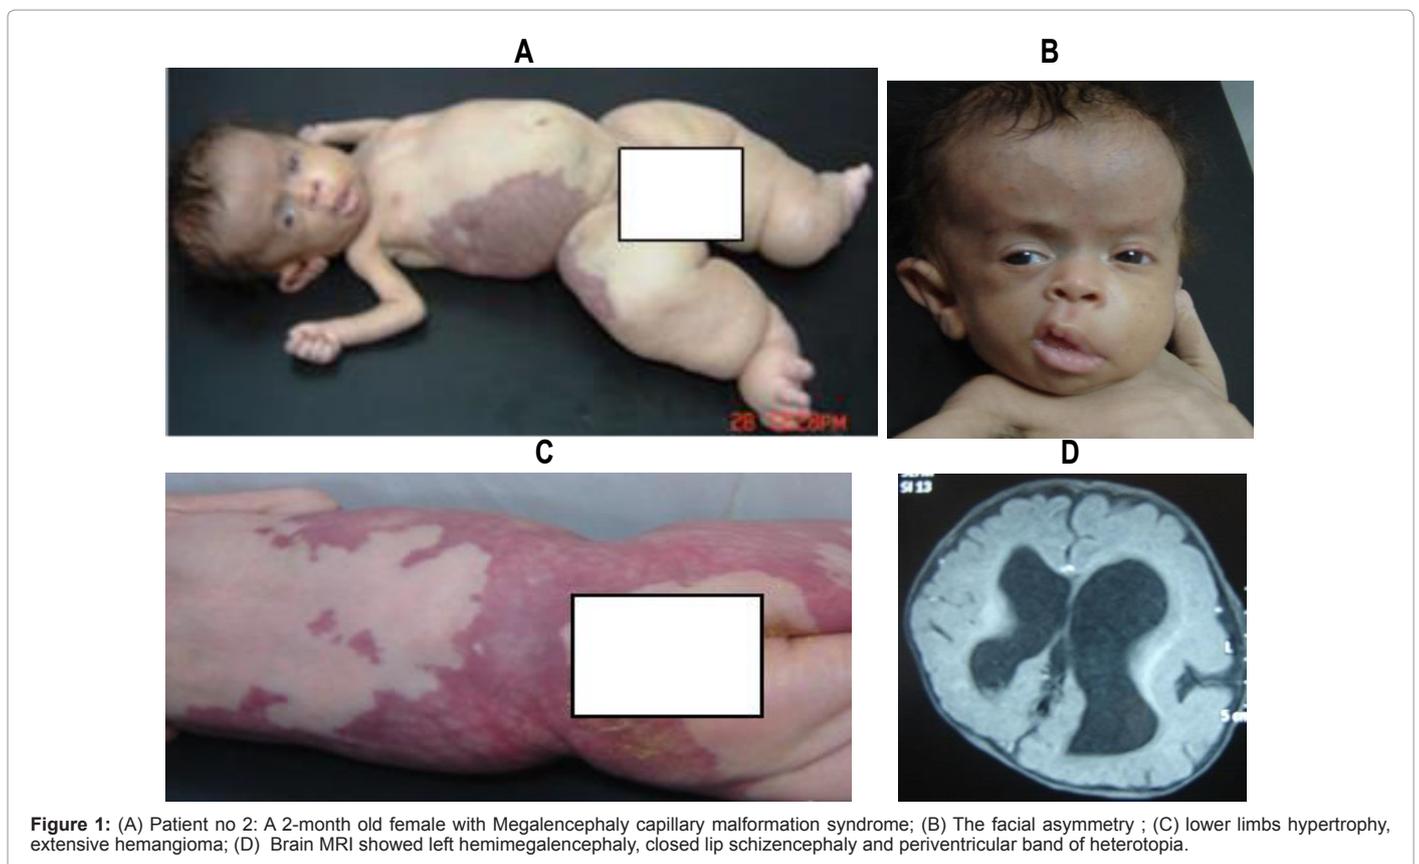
(A) Patient no 2: A 2-month old female with Megalencephaly capillary malformation syndrome; (B) The facial asymmetry ; (C) lower limbs hypertrophy, extensive hemangioma; (D) Brain MRI showed left hemimegalencephaly, closed lip schizencephaly and periventricular band of heterotopia.
